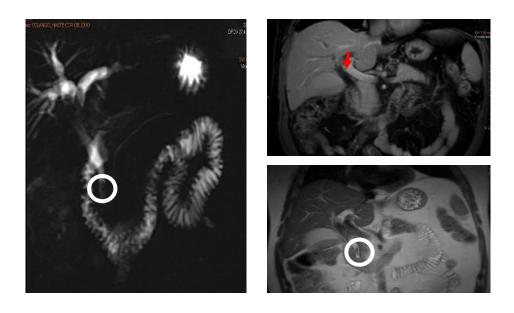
MRI imaging shows complete response to treatment (red arrow). Marked dilation of the bile duct by a biliary mud mold (white circle).
